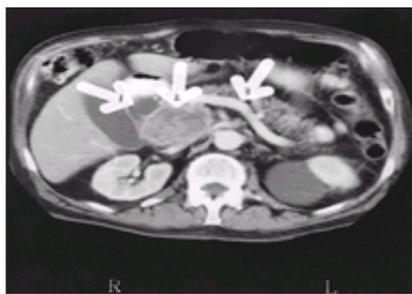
Computed tomography scan of the abdomen of a 47-year-old woman with epigastric pain and jaundice. The computed tomography shows a large mass in the head of the pancreas (arrow 2), dilatation of the common bile duct (arrow 1), and dilatation of the pancreatic duct (arrow 3). L, left; R, right.
